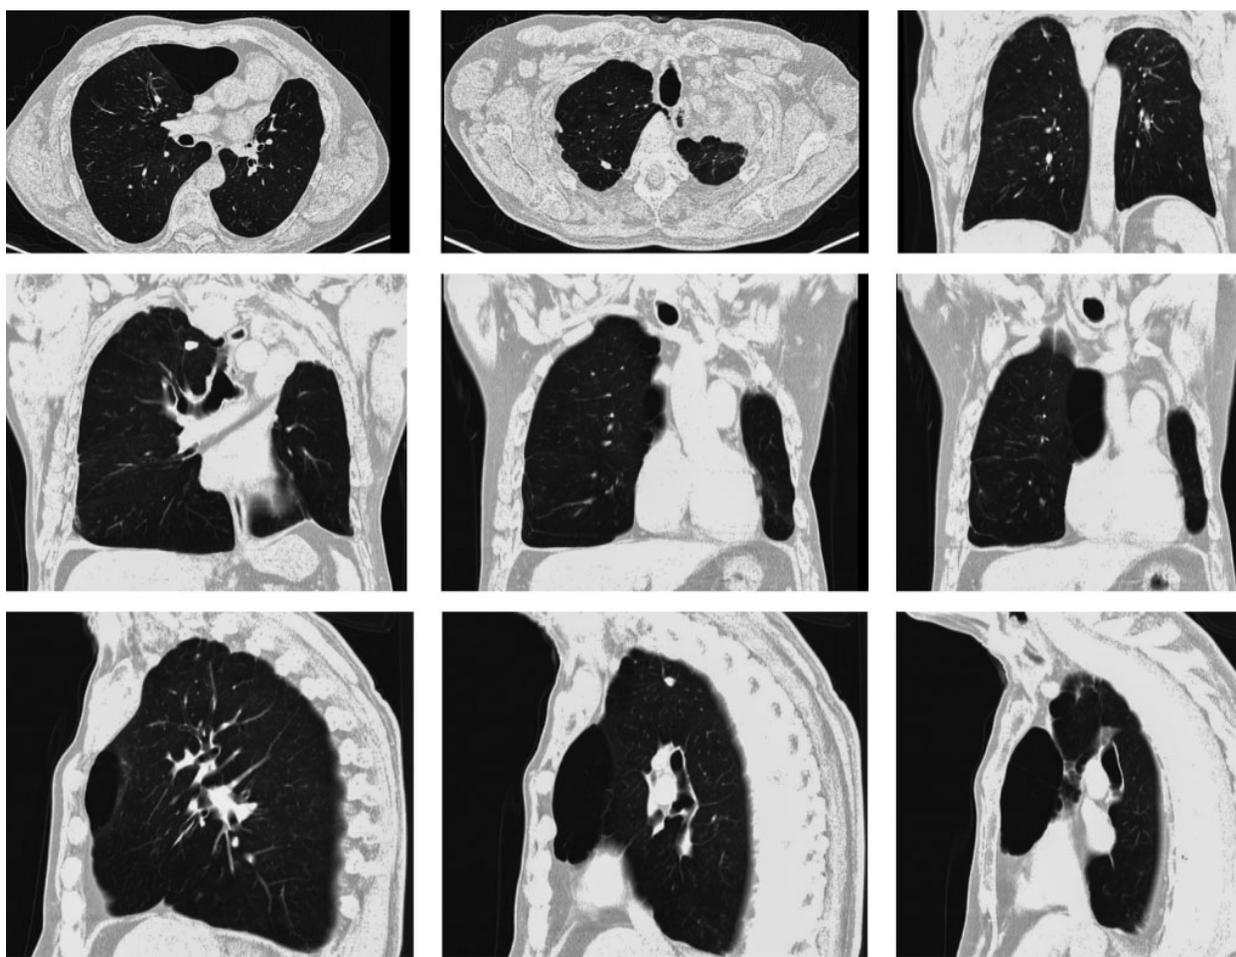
CT scan of the thoracic cavity dated 6 March 2024
